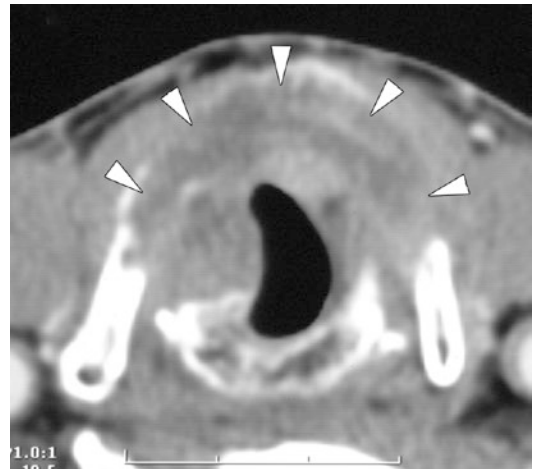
Patient presenting with history of chronic laryngitis since 2 years. Endoscopic examination shows edema of the anterior commissure, and scarring of the vocal cords. The axial CT image shows thickening and distortion of the laryngeal soft tissues, as well as osteolysis and expansion of a large part of the thyroid cartilage (arrowheads). These findings are very suspect for a malignant lesion. Deep biopsy revealed squamous cell cancer
